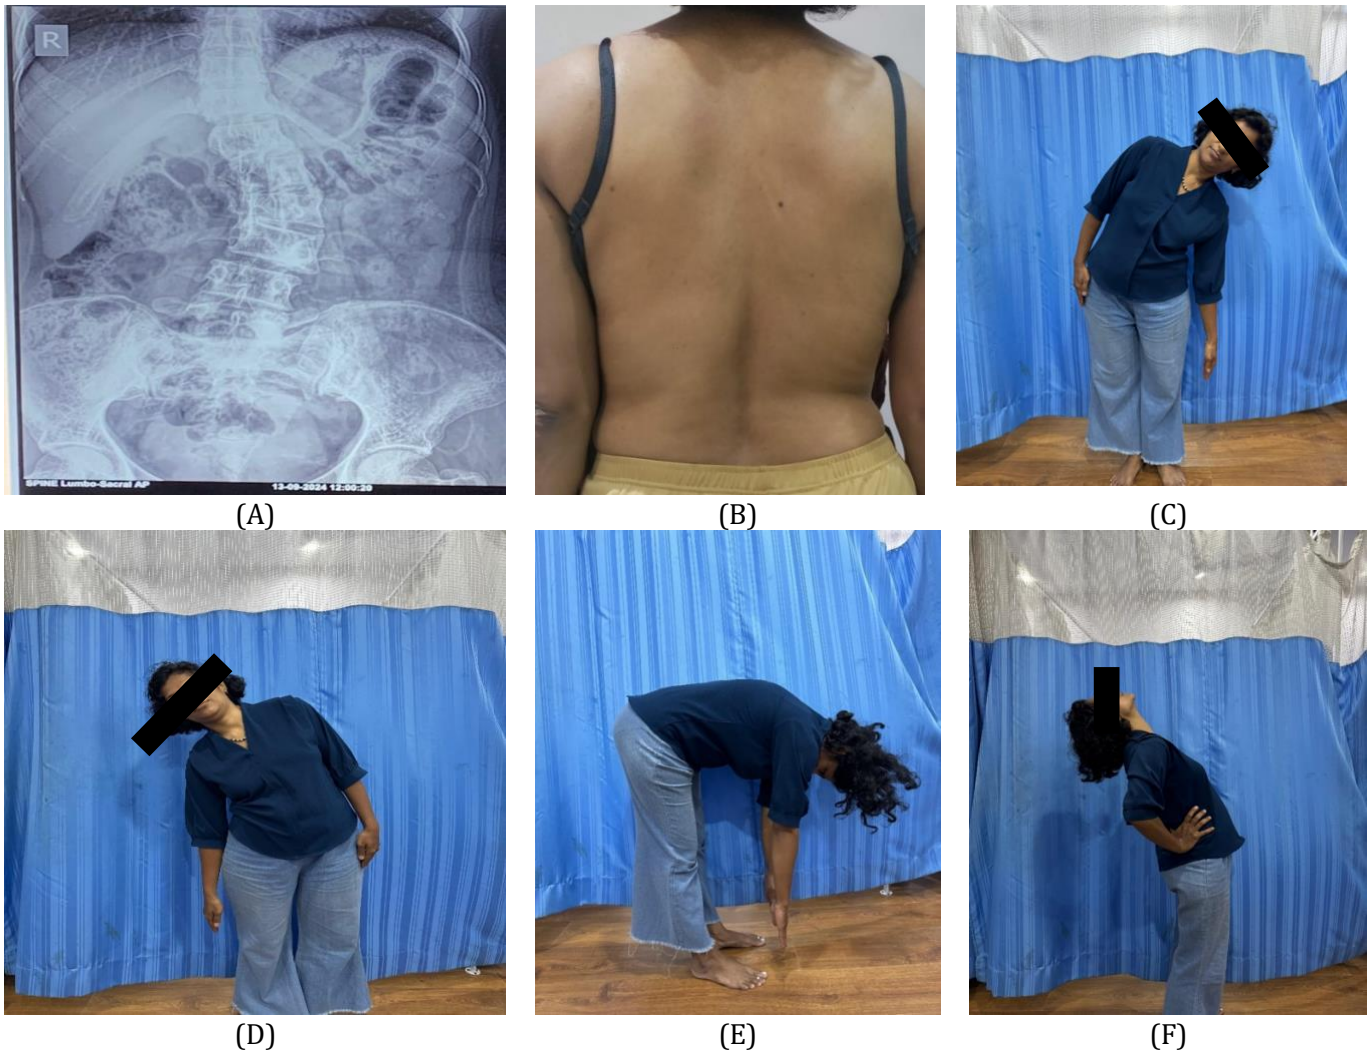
X-ray of congenital scoliosis^A ; Scoliotic changes^B ;Left lateral lumbar flexion^C ; Right lumbar lateral flexion^D ; Lumbar flexion^E ; Lumbar extension^F.
